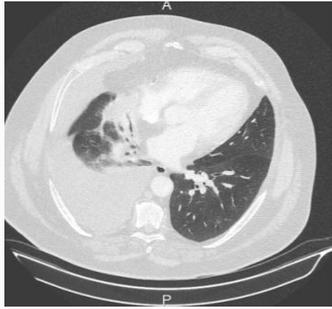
First pulmonary Computed Tomography (CT) scan of (10/2018).
